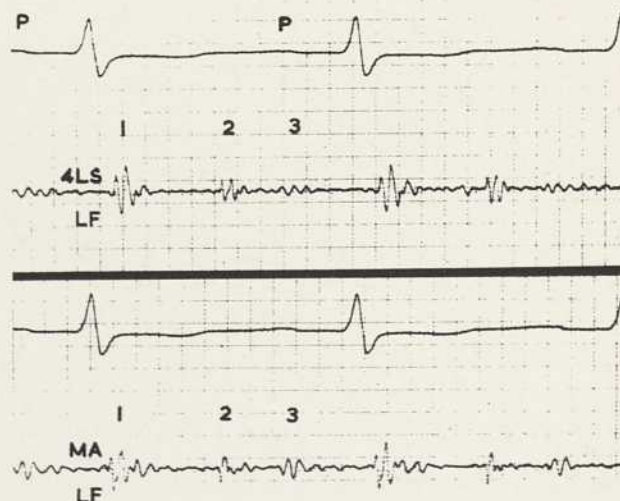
Low frequency recordings from the fourth left intercostal space parasternally (4LS) and apex (MA) showing the loud third heart sound. (Patient P.B.)
